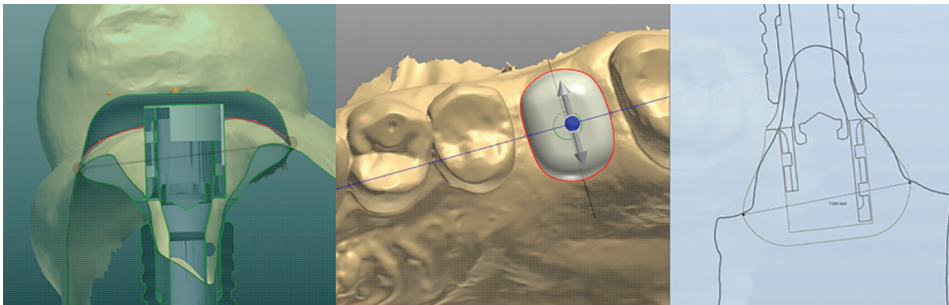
Information from a digital intra-oral impression and a CBCT prior to tooth extraction can be used to recreate the ideal emergence profile as a customized abutment.
